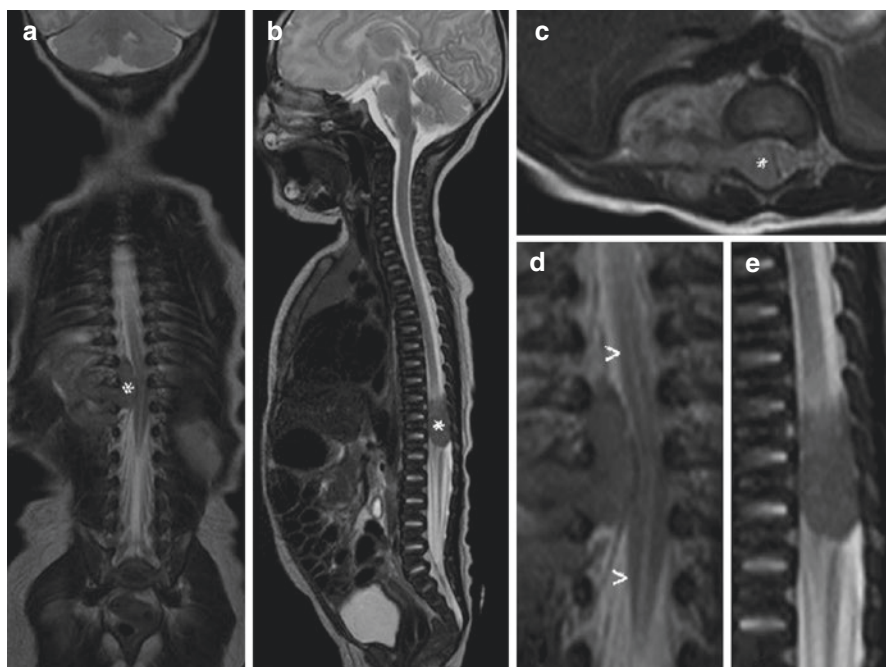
Complete MRI scan in a baby harbouring a PNT with evidence of SCI. A reliable three planar T2WI sequence should avoid 3D acquisition with postprocessing reconstruction; native coronal (a), sagittal (b) and transverse (c) sequences have to cover the whole length of the backbone in order to depict multiple levels of invasion and coexisting abnormalities. A typical dumbbell appearance of PNT invasion is shown (asterisk), passing trough the enlarged foramina and dislocating/compressing the spinal cord. Magnification views (d, e) show the normal appearance of the central canal (less than sign), often misread as T2WI hyperintensity of the spinal cord
